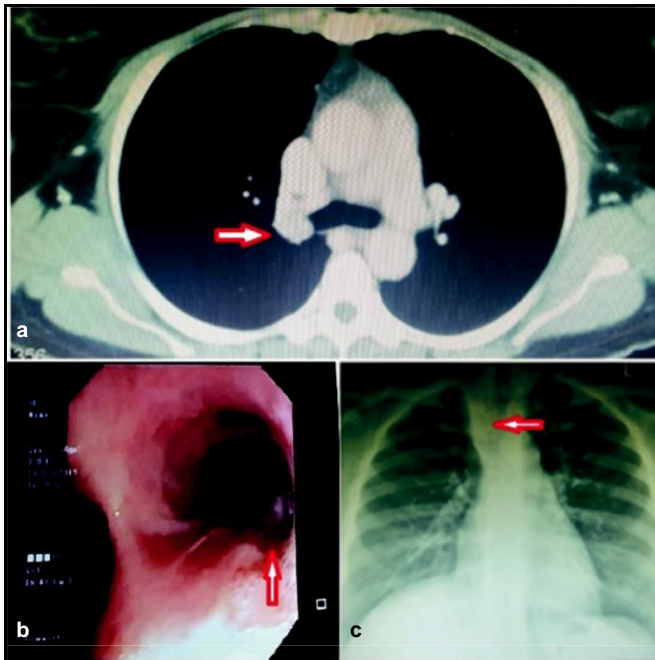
a) CT thorax showing tumour at the right main bronchus (RMB). b) Bronchoscopy view of carina with tumour seen at RMB. c) Preoperative CXR showing collapsed right upper lobe.
